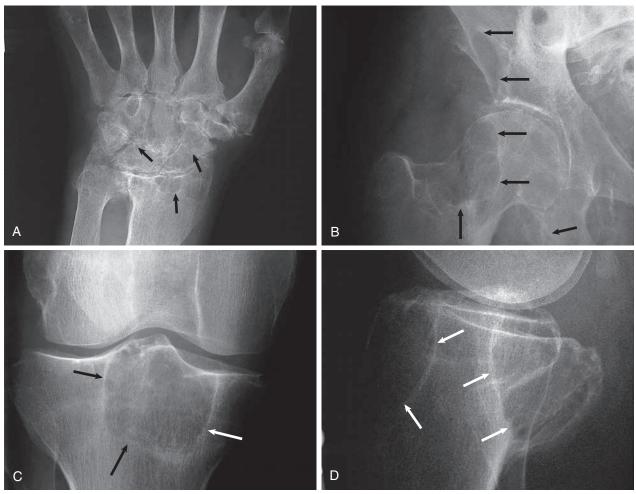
Peripheral bone cystic radiolucencies in $A\beta_2M$ amyloidosis. Radiographic findings in a long-term hemodialysis patient. (A) Multiple cystic lesions (arrows) are present in the hand bones. (B) Large cysts (arrows) in the neck of the femur and adjacent pelvic bones. (C and D) Anterior and lateral views of the head of the tibia with two very large, cystic lesions (arrows) resulting in posterior bulging of the tibial plateau.
